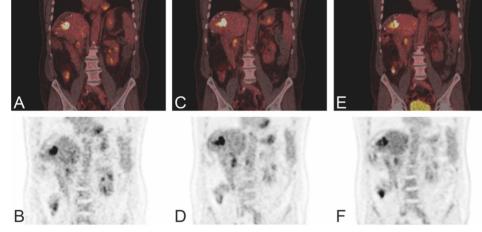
Response monitoring palliative rectal cancer. Representative PET/CT (A, C, E) and PET (B, D, F) images before treatment (A, B), one week into treatment (C, D) and after 3 cycles of treatment are depicted (E, F).
